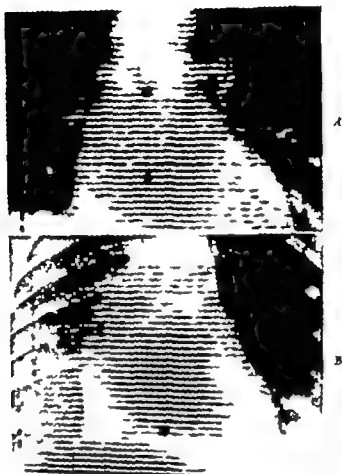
A Photocan superimposed on the chest radiograph of a patient with tight constrictive pericarditis. The cardiac pool is almost as large as the heart shadow. B Photocan superimposed on the chest radiograph of patient with constrictive pericarditis in whom there was no effusion, but a significant layer of caseous material was found at necropsy. This shows a small cardiac pool surrounded by a halo of decreased radioactivity and large cardiopericardic gap.
